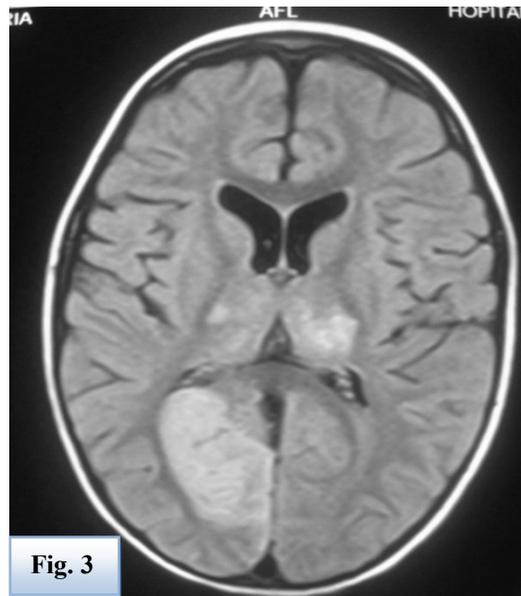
Brain MRI in axial slices showing ischemic areas in hypersignal FLAIR.
